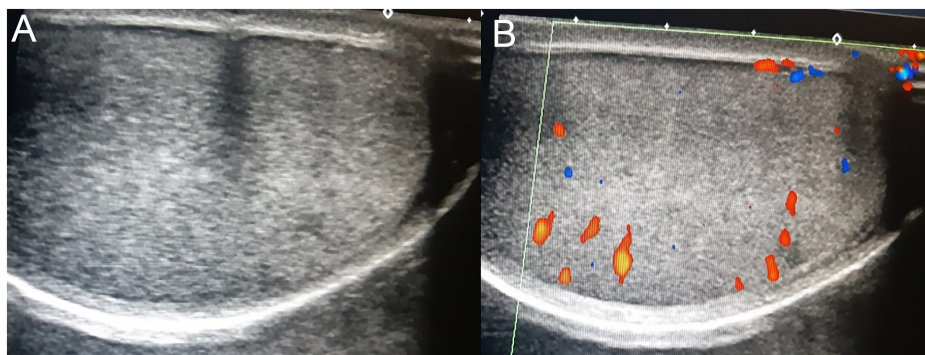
(A, B) The parenchymal echo and the blood flow of the left testis were in normal ranges on the grayscale (A) and Doppler ultrasound examination (B), respectively.
